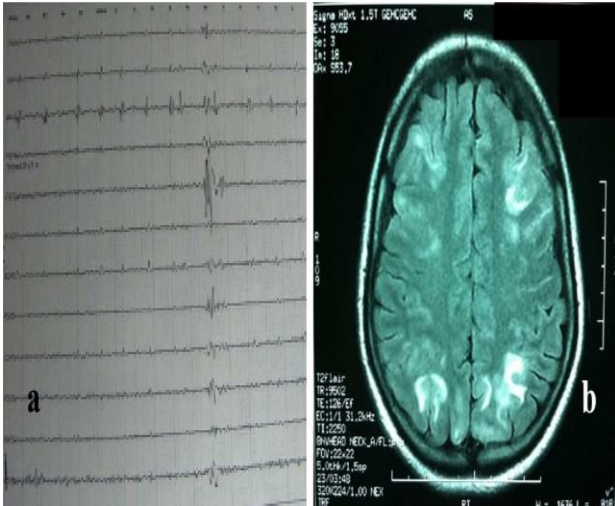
(A and B): Electroencephalogram: a diffuse paroxysmal activity for short time and brain MRI, axial section, FLAIR sequence: hypersignals of the subcortical white matter at the frontal and bilateral parietal areas.
